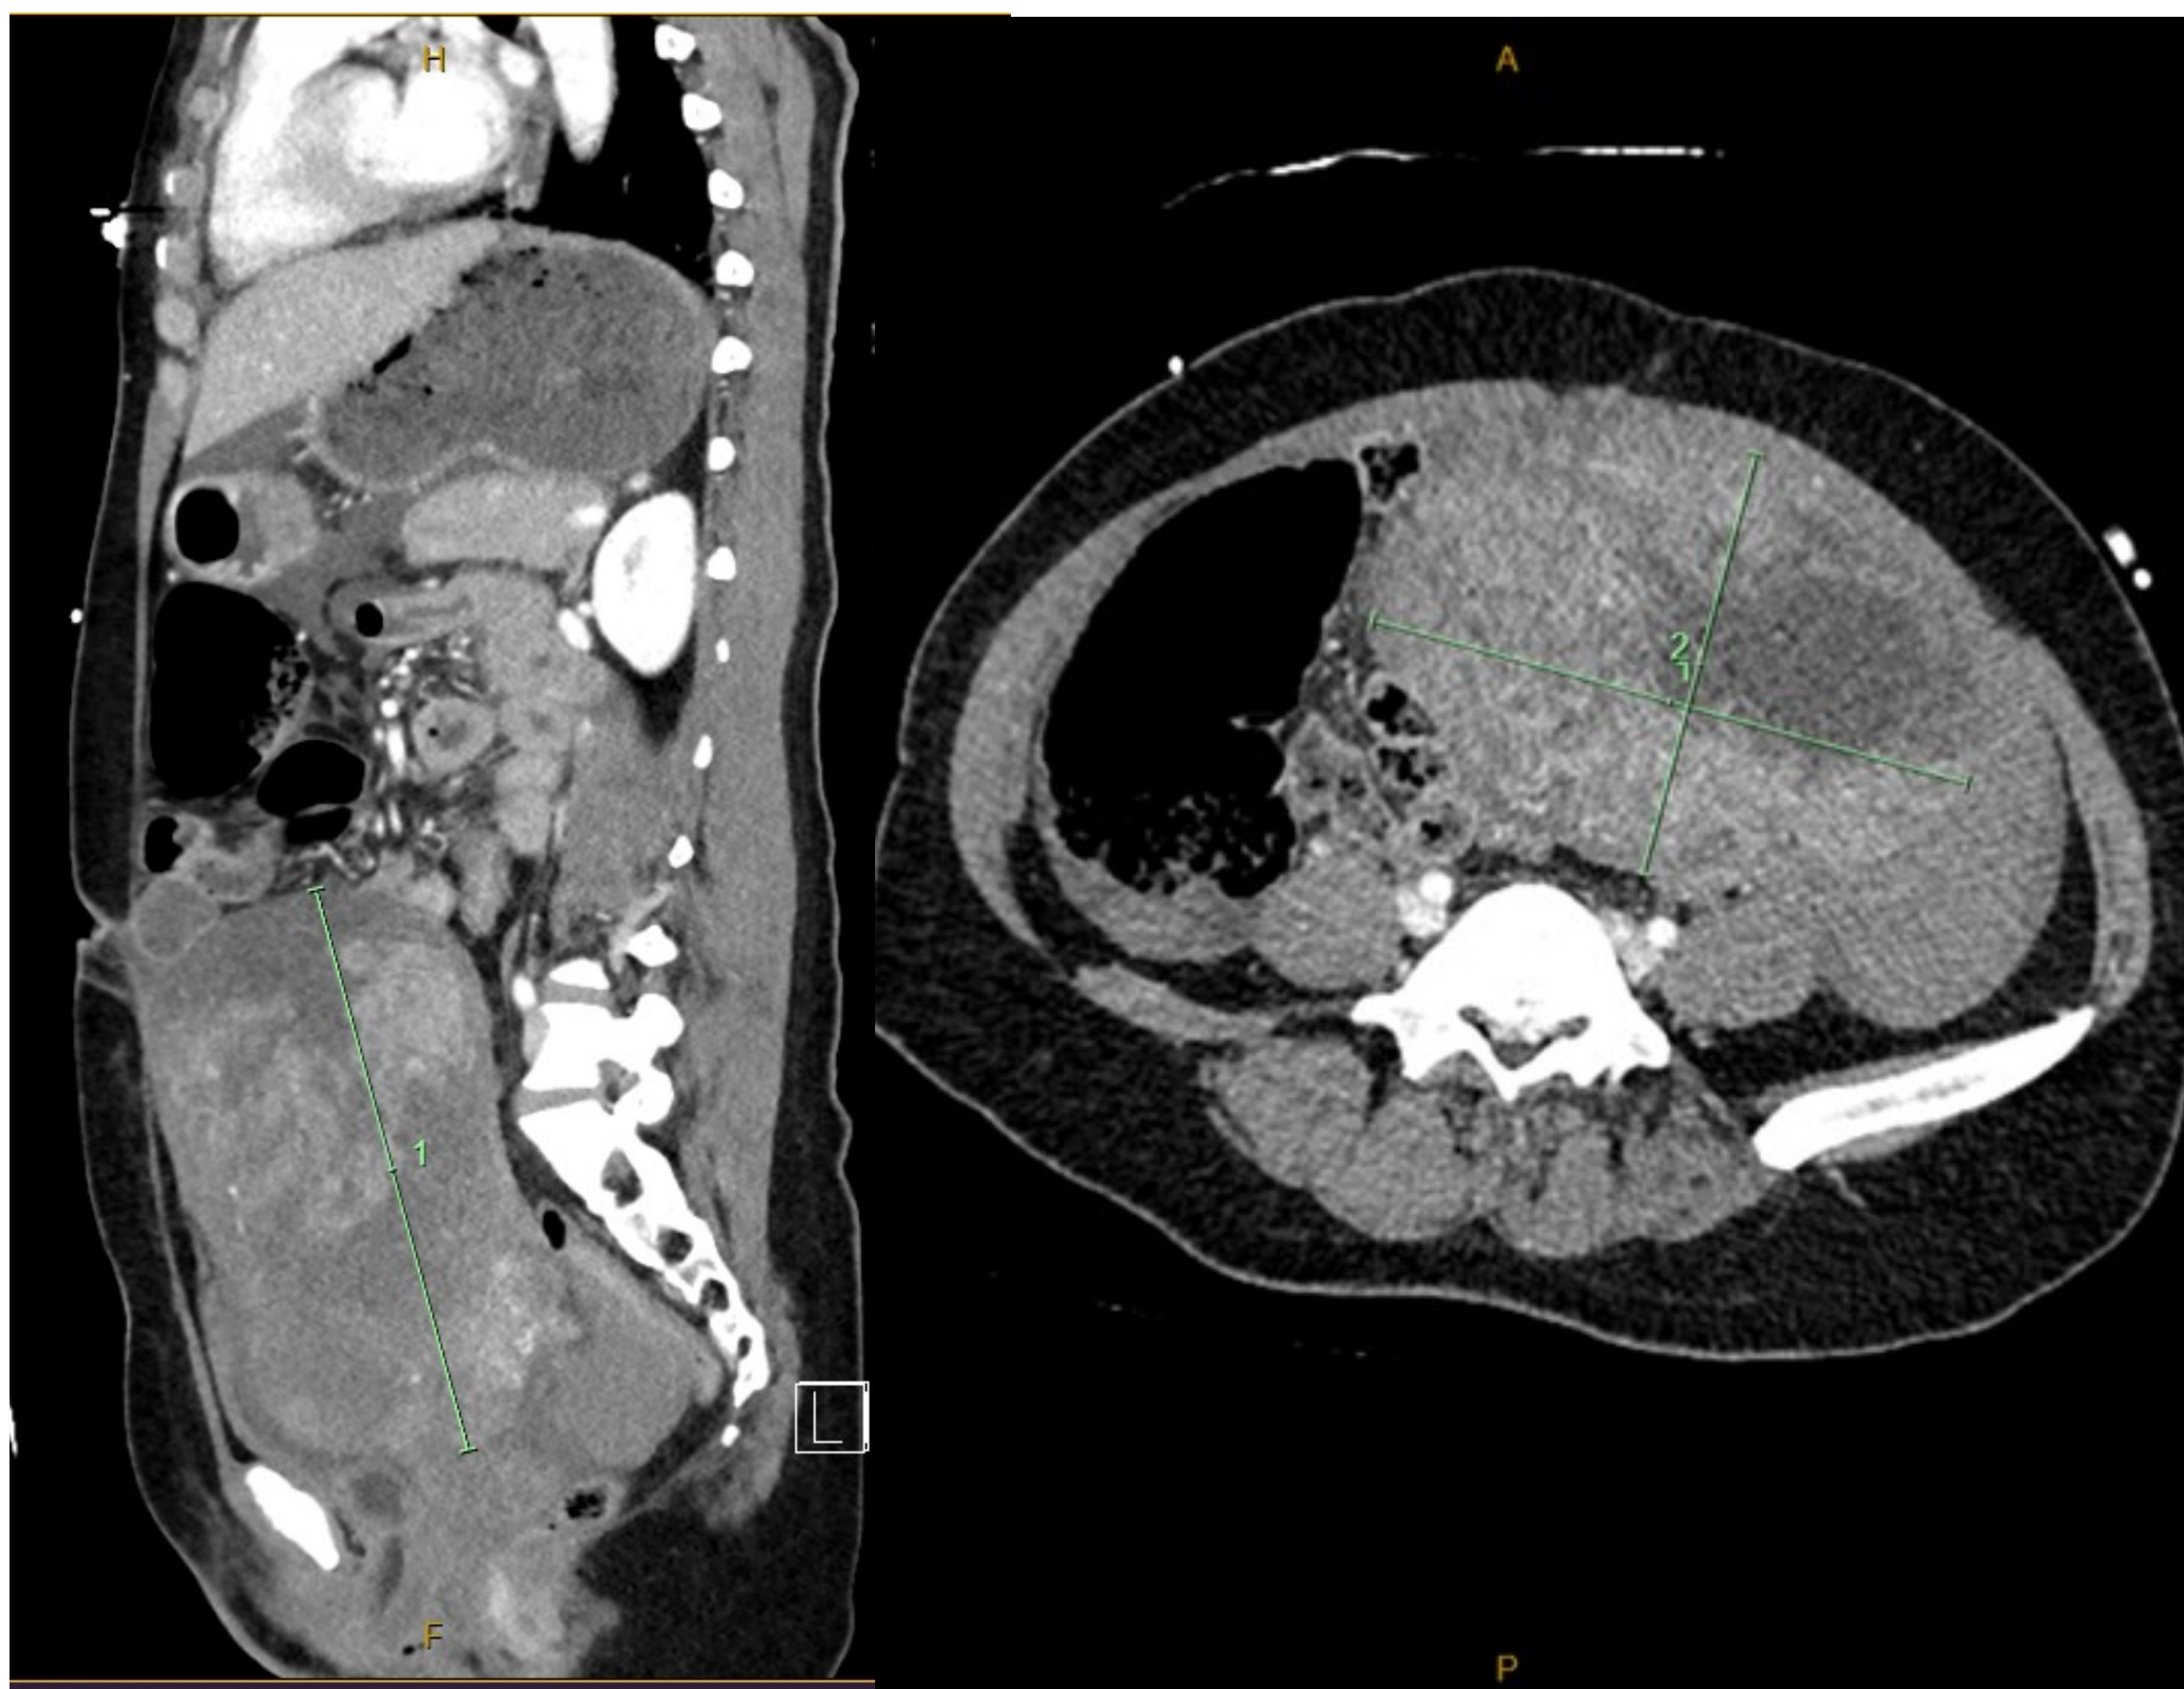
CT scan showing multi-fibroid uterus and hemoperitoneum
